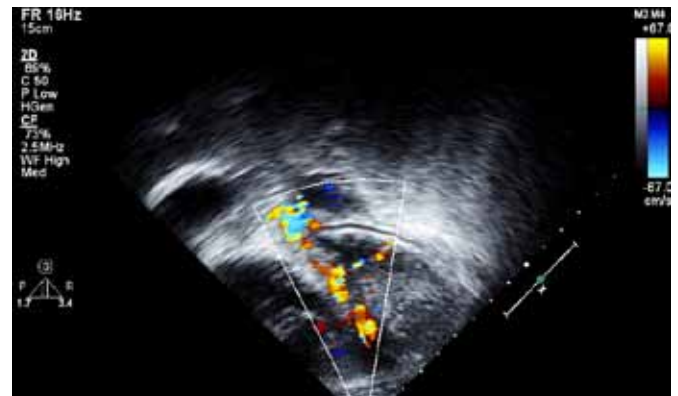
Apical 4-chamber view showing multiple, predominantly diastolic, abnormal septal color flows indicating septal perforator coronary arteries.
